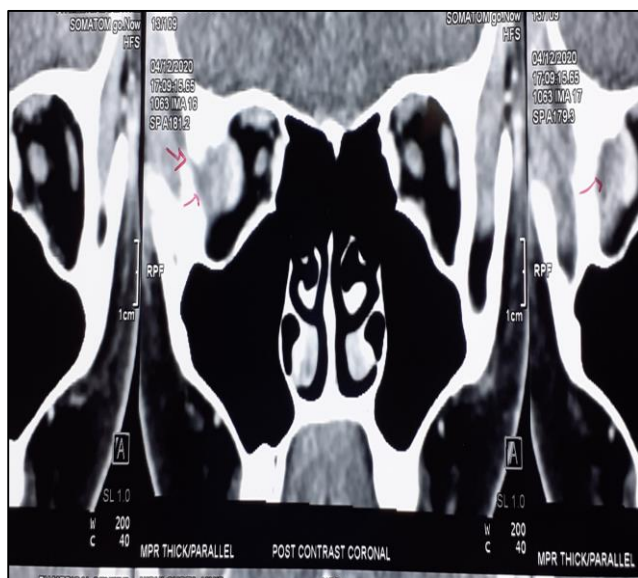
CT PNS showing periosteitis of right greater wing of sphenoid and cystic well-defined lesion without infiltration of lateral recti right.
